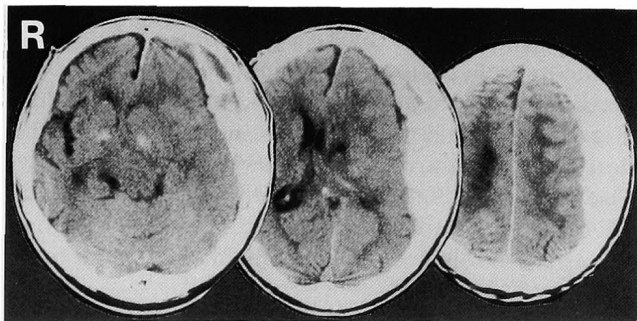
Emergent computed tomography scans 33 hours after the accident showing a typical acute subdural hematoma with brain herniation.
